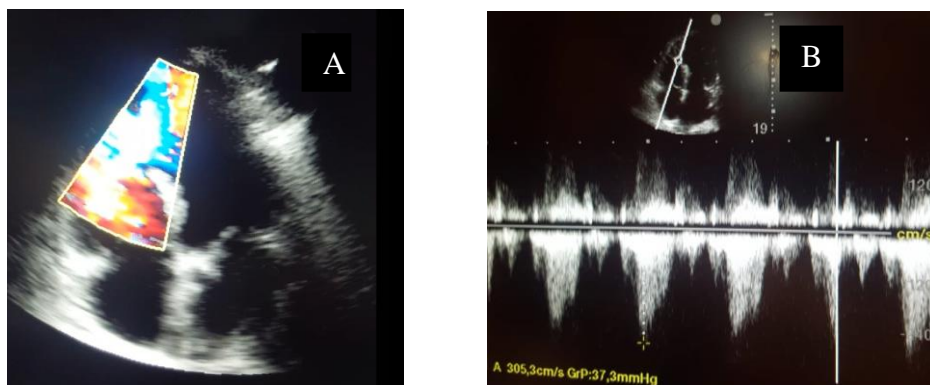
A : two-dimensional transthoracic apical four-chamber view on color doppler shows the left-to-right shunt.
